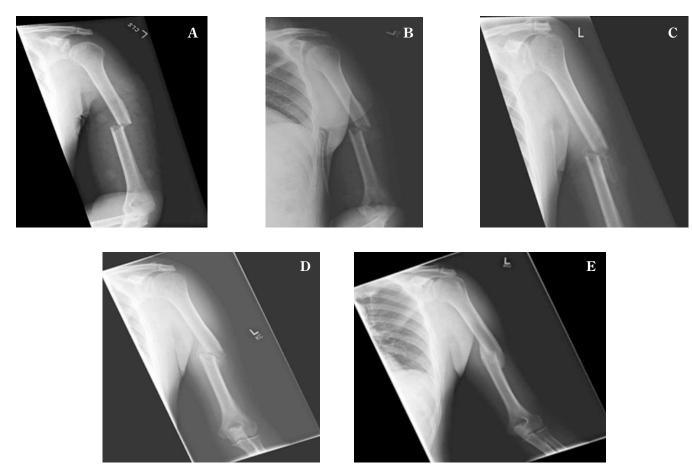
a.) Immediate post-brace radiograph, b.) 2 week follow-up, c.) 3 week follow-up, d.) 6 week follow-up, e.) 1 year follow-up
